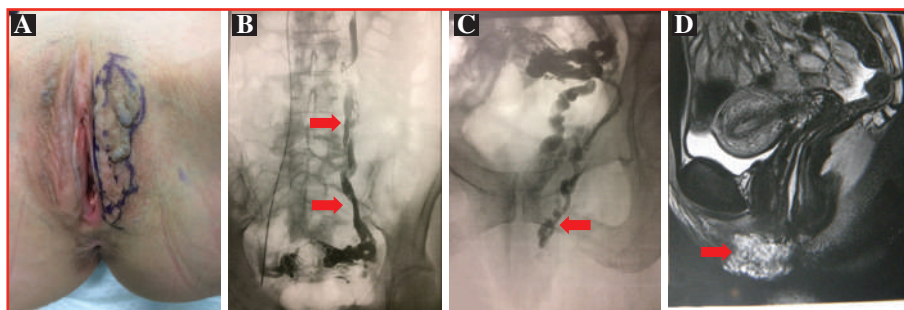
VM of the labia majora associated with venous troncular insufficiency. (A) Clinical appearance. (B) Phlebography: venous reflux of the left ovarian vein (arrow: ovarian vein). (C) Phlebography: venous reflux in the veins of the peritoneovaginal canal (arrow). (D) MRI on T2 fat saturation: heterogeneous hyper signal of labial VM (arrow).
